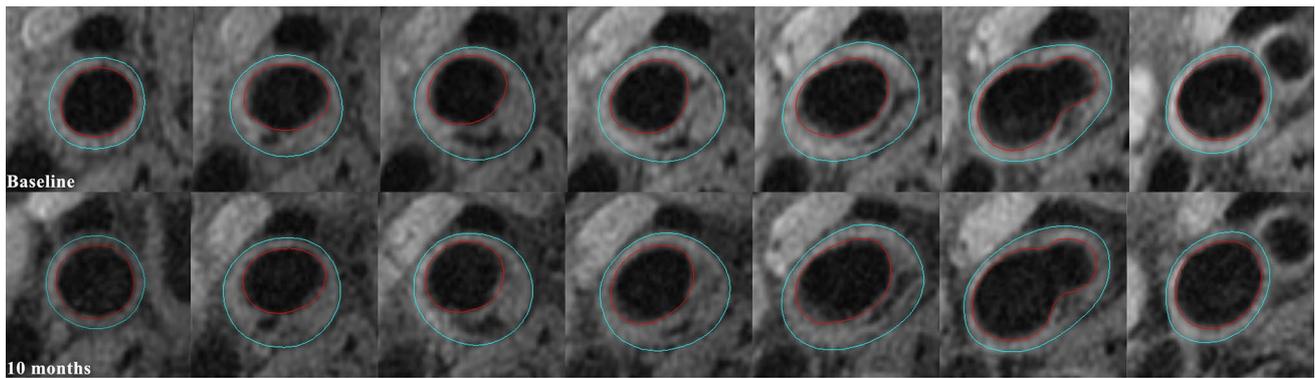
Example for morphological measurements of carotid artery. The picture shows that the lumen in red and outer wall boundary in blue of the carotid artery are identified and outlined on T1-weighted images. Carotid wall volume is calculated by multiplying the slice
